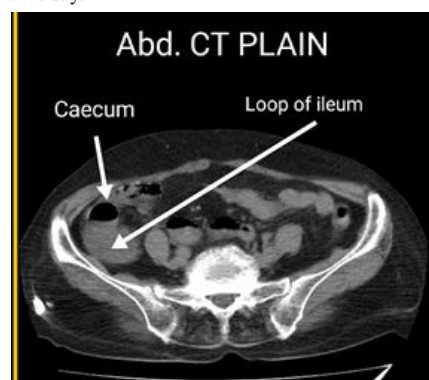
Computed Tomography (Plain) of abdomen showing retrocecal herniation.
